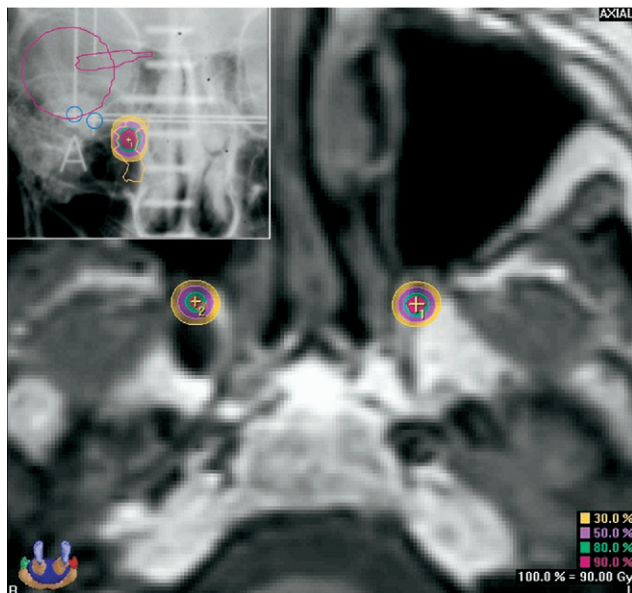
Axial T1-weighted magnetic resonance imaging with isodose wash superimposed for the bilateral sphenopalatine ganglia of Patient 5. (Insert) Anteroposterior X-ray of the skull with isodose wash superimposed demonstrating the locations of the target on plain X-rays as correlated by the stereotactic coordinates.
